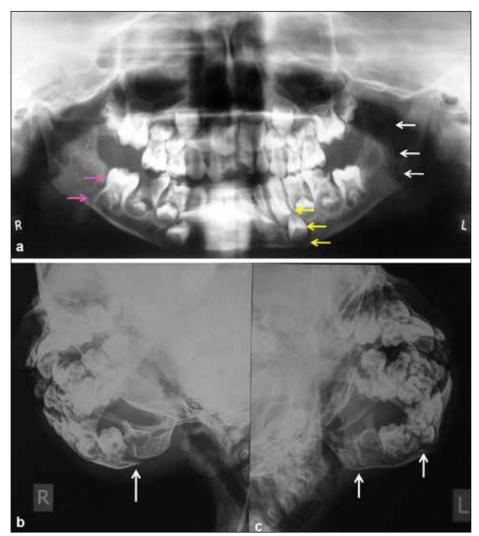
(a) Orthopantomogram showing fracture at right angle, left parasymphysis and ramus of mandible (b) fracture lines evident on lateral oblique view of mandible
